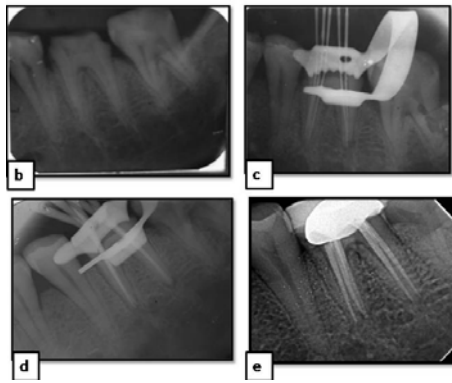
(a) Pre-operative view; (b) Working length; (c) Master cone; (d) Obturation radiographs
